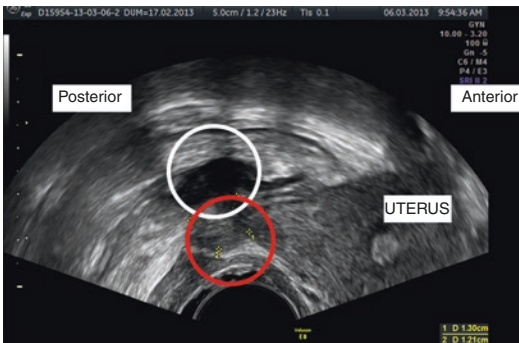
A diabolo-like nodule as visualized using transvaginal ultrasonography. In the white circle, the rec-tosigmoid nodule; in the red one, the forniceal nodule
